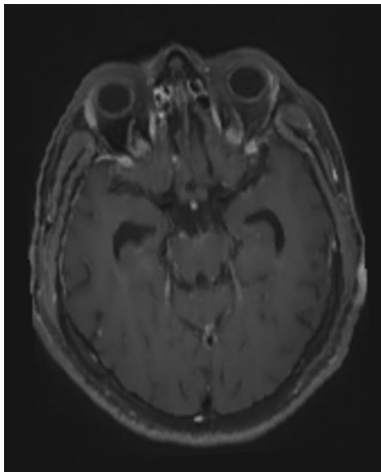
Interval increase in sulcal and folial FLAIR signal changes with post contrast enhancement with diffuse involvement of the bilateral cortical sulcal and cerebellar folial regions.
